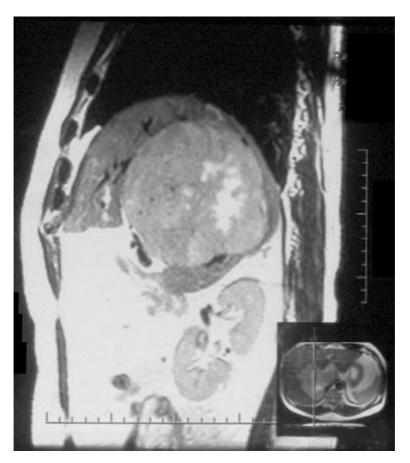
MRI showing a giant tumor in the caudate lobe
